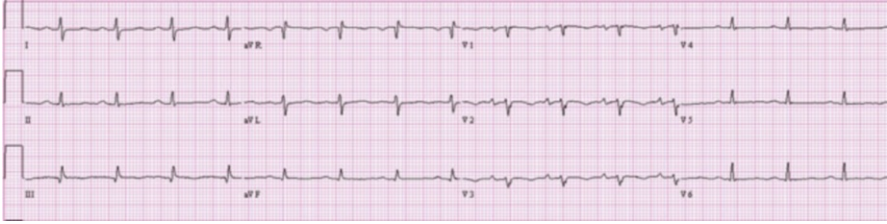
12-lead echocardiogram showing an incomplete right bundle branch block pattern with rightward axis
